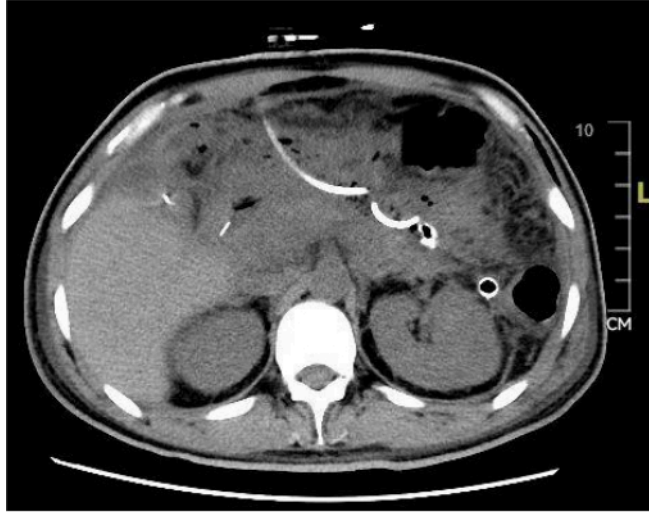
Postoperative CT scan. The postoperative CT scan shows a significant reduction in peripancreatic fluid accumulation and necrotic tissue after surgery. [Please click here to view a larger version of this figure.](#)
